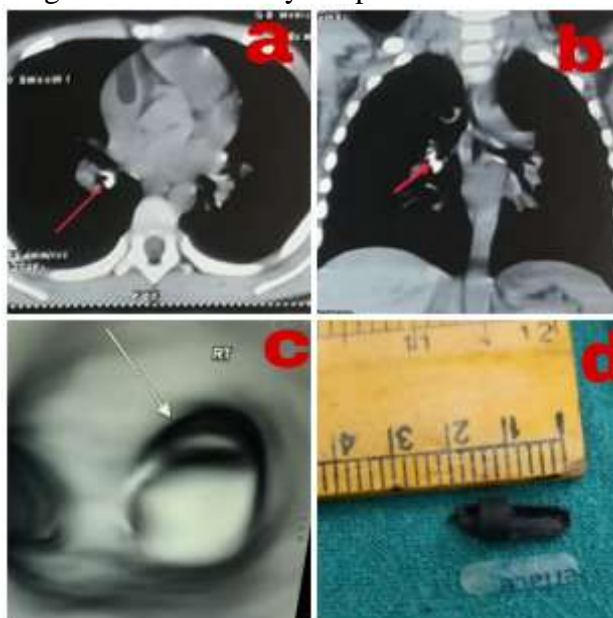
(a),(b),(c): axial, coronal and virtual bronchoscopic image of CT scan
